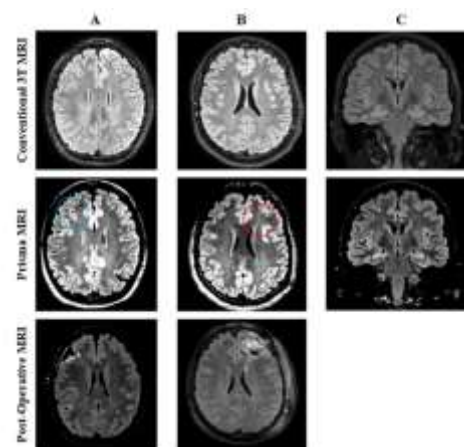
Comparisons of conventional (upper panel) and Prisma (middle panel) magnetic resonance imaging (MRI) scans with post-operative MRI if applicable in the lower panel. (A) Focal cortical dysplasia (blue circle) in patient 2. Axial T2 fluid-attenuated inversion recovery (FLAIR) weighted image on conventional 3 Tesla (T) MRI (upper panel) and Prisma 3T MRI (middle panel) demonstrating subtle cortical blurring in the right frontal cortex. Post-operative MRI (lower panel) with interval resection of focal cortical dysplasia. (B) Focal cortical dysplasia (red circle) in patient 3. Axial FLAIR weighted image on conventional 3T MRI (upper panel) and Prisma 3T MRI (middle panel) demonstrating left frontal linear hyperintensity extending from the left frontal horn of lateral ventricle to cortex. Post-operative MRI (lower panel) demonstrates interval resection of focal cortical dysplasia. (C) Possible hippocampal sclerosis in patient 12. Coronal FLAIR weighted image on conventional 3T MRI (upper panel) and Prisma 3T MRI (lower panel) demonstrating bilateral hippocampal hyperintensities. This patient is currently scheduled for bilateral RNS placement.
